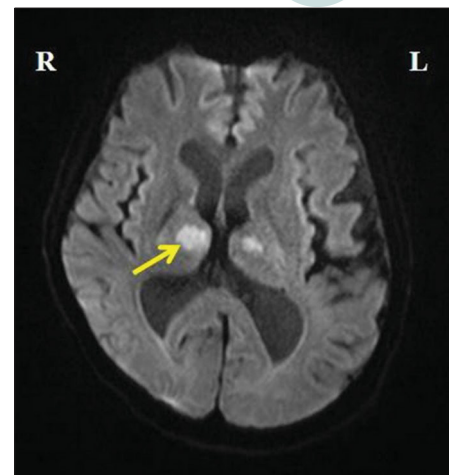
Magnetic resonance imaging of the brain (T1-weighted sequence) showing focal areas of restricted diffusion in the medial part of the thalami bilaterally and in the rostral part of mid-brain (right > left)
